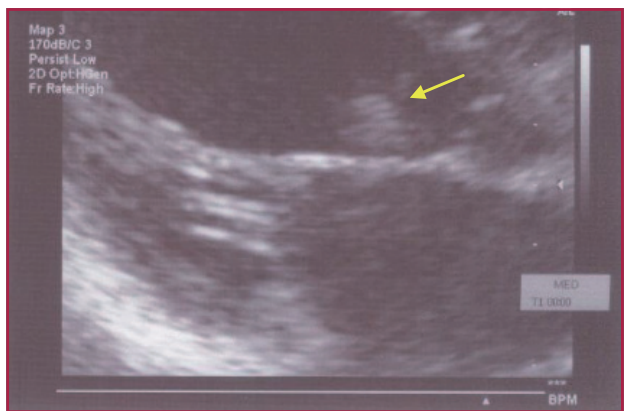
Transthoracic echocardiography. Parasternal long axis view with zoom on the formation described above, showing lower echo-refraction with respect to the valve structure, and the vegetation occupying almost 50% of the left ventricular outflow tract diameter
